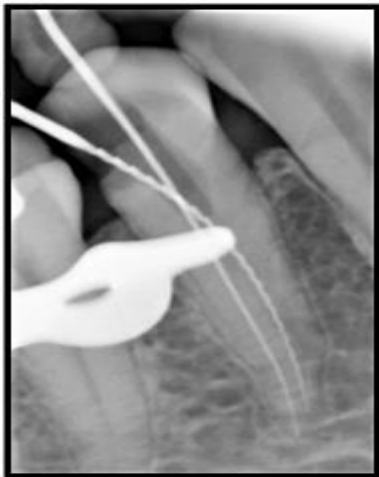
Radiograph showing #15 spreader and #15H file to distinguish between buccal canal and lingual
